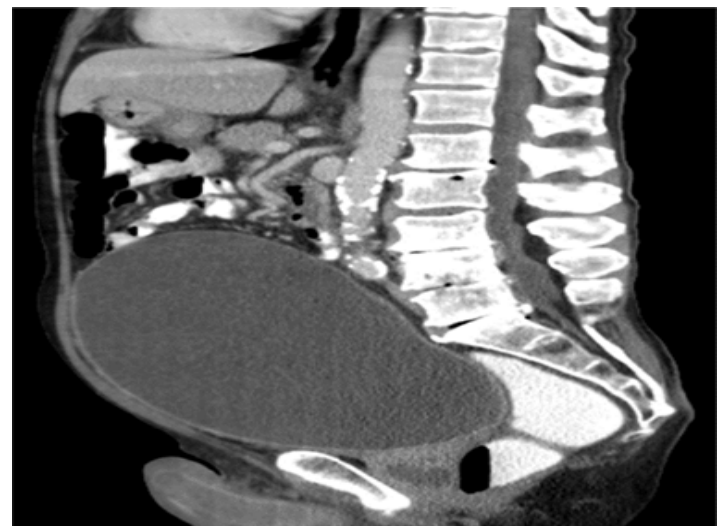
CT image showing a extremely dilated urinary bladder
